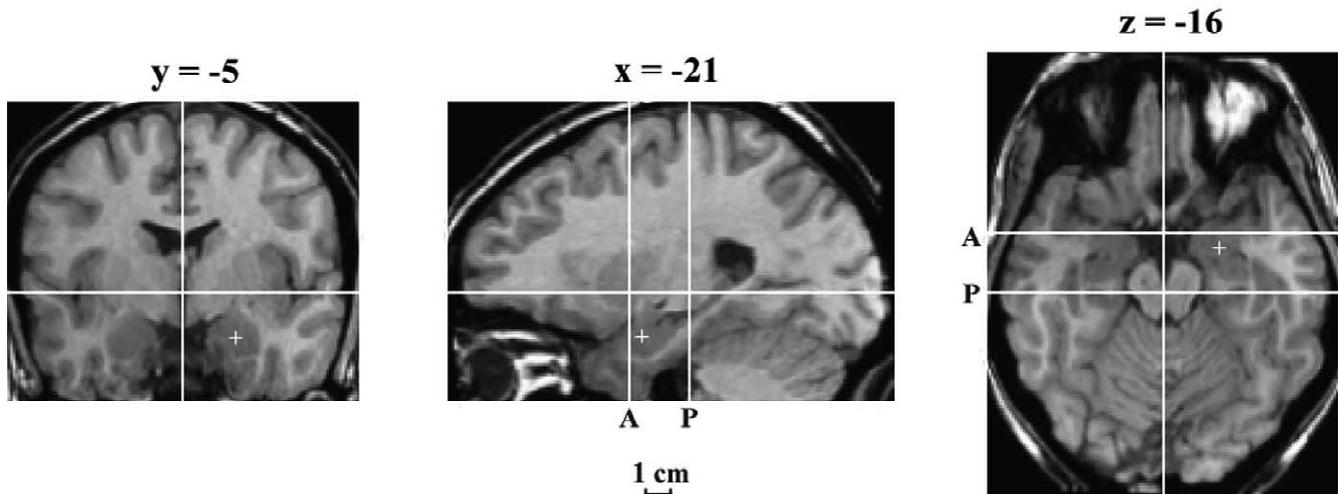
A structural $T-1$ weighted MRI of a subject with a typically positioned amygdala. The subject's MRI was aligned along the intercommissural plane and linearly warped to Talairach space. Talairach coordinates represent; (x) mm lateral to the midline (left = -), (y) mm anterior–posterior to the anterior commissure (posterior = -), and (z) mm inferior–superior to the anterior commissure–posterior commissure plane (inferior = -). The white horizontal line in the sagittal and coronal slices represents the intercommissural plane ($z = 0$). The lines marked 'A' and 'P' in the transverse and sagittal slices run through the anterior and posterior commissures at $y = 0$ and $y = -23$, respectively. The crosshairs lie near the central point of the left amygdala and indicate the location of the other two displayed slices. Note that at this resolution (which is typical of anatomical MRIs collected as part of functional studies), it is difficult to visualize the borders of the subnuclei or even the border of the amygdala relative to neighboring gray matter regions.
